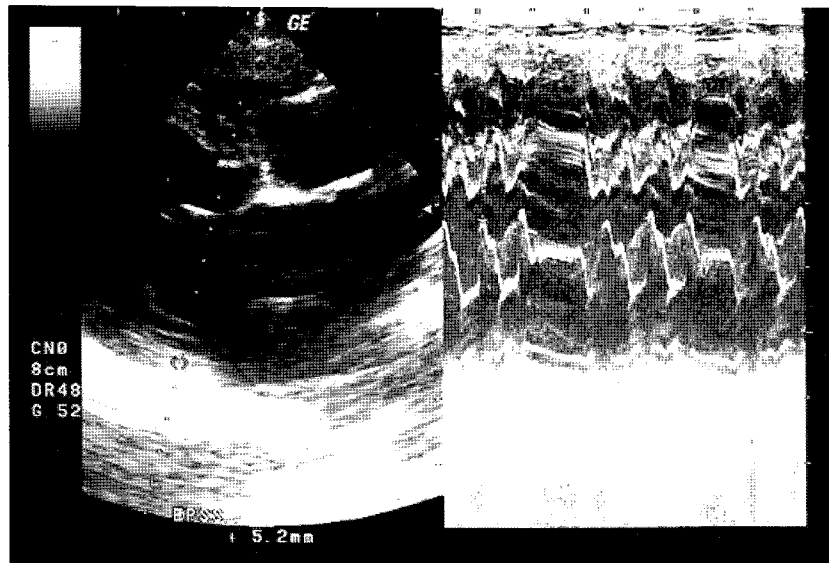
The 2D and M-mode echocardiography taken from right parasternal long axis view of four chamber showed increased EPSS.
